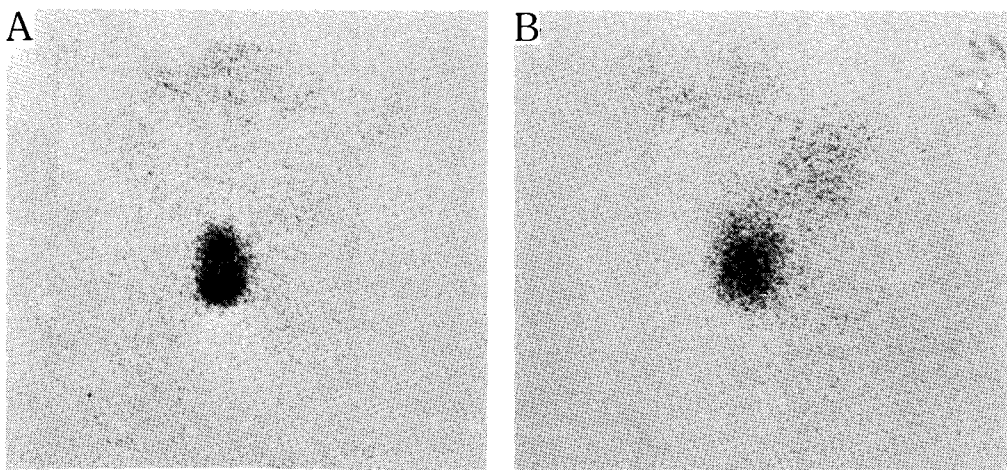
Case IV. Anterior (a) and lateral (b) views of  $^{99m}\text{Tc}$  scintigraph show a oval increased activity at midline of upper anterior neck, which corresponds to clinically palpable mass on neck.
